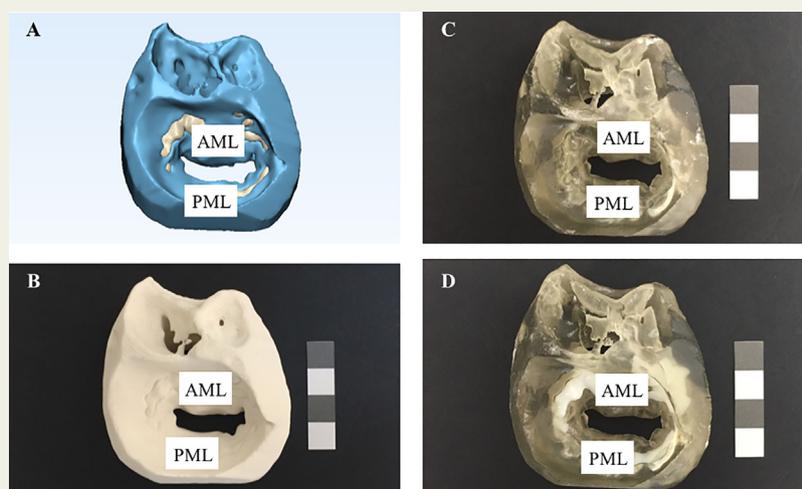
Virtual and 3D printed MV models for patient 4 with MV calcification. Cardiac CT imaging data was used to produce a virtual 3D model (A), which was 3D printed in three different materials to compare rigid (B), flexible (C) and multi-material (D) 3D prints. Abbreviations: 3D, three dimensional; MV, mitral valve; AML, anterior mitral leaflet; PML, posterior mitral leaflet. [Note: calibration inset, 10 mm x 10 mm squares].
